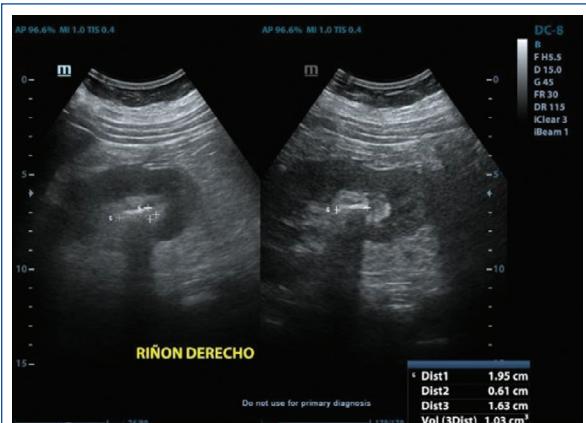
Ultrasonido renal con presencia de lito renal derecho de 1 cm.
